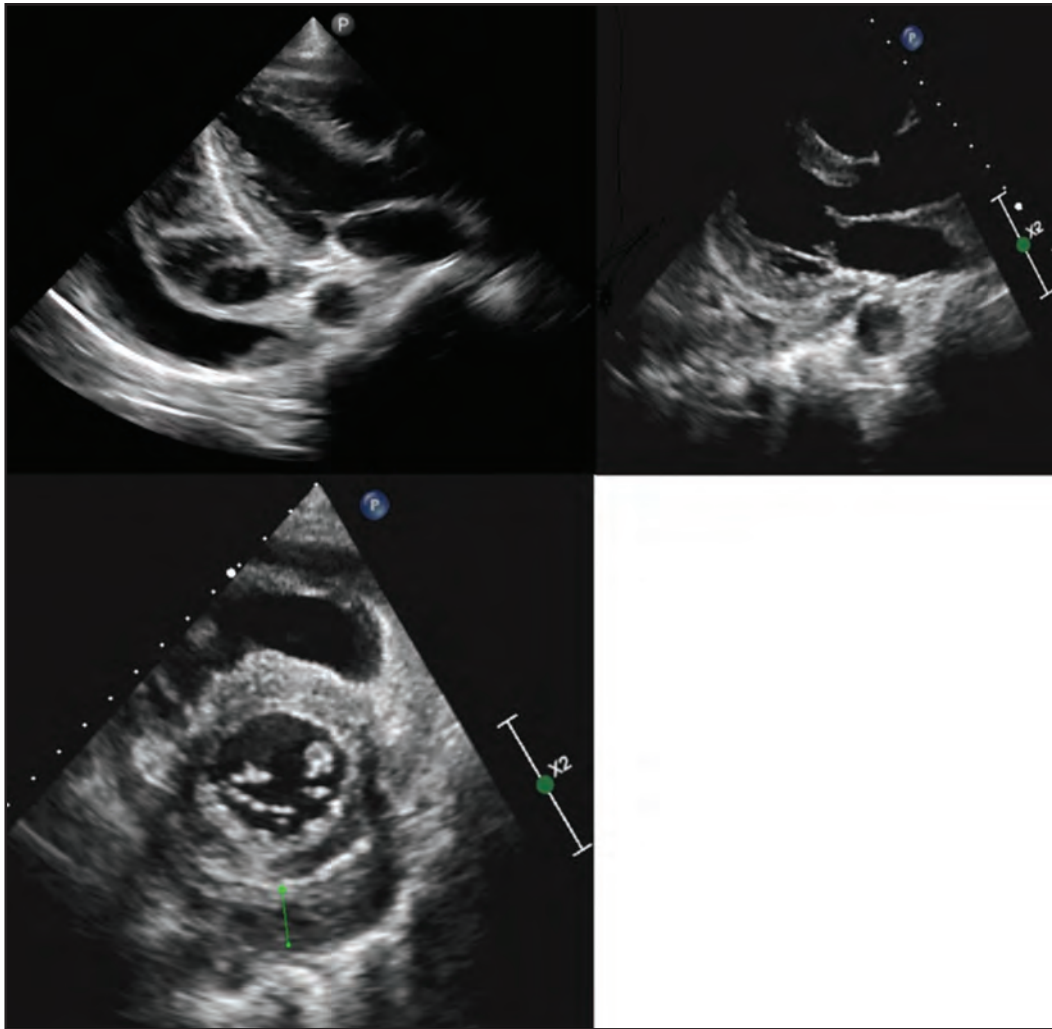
(A) Parasternal long axis view showing septated pericardial fluid at the posterior pericardium (white arrow). Pleural effusion was also seen (dotted arrow). (B) Parasternal long axis view and (C) short axis view showing organised pericardial effusion
